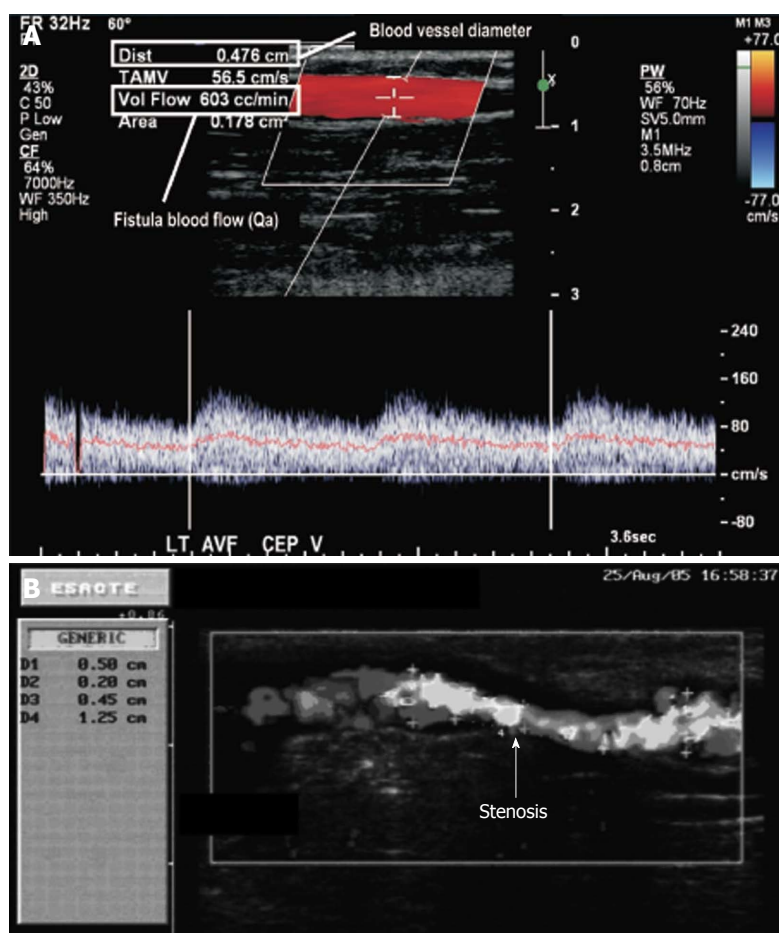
(A) Velocity pulse from Doppler ultrasound, and (B) detection of stenosis and estimating its grade using Doppler ultrasound^[8,9]. AVF: Arteriovenous fistula. Reprinted from Campos *et al*^[8] and Feddersen *et al*^[9], with permission.
